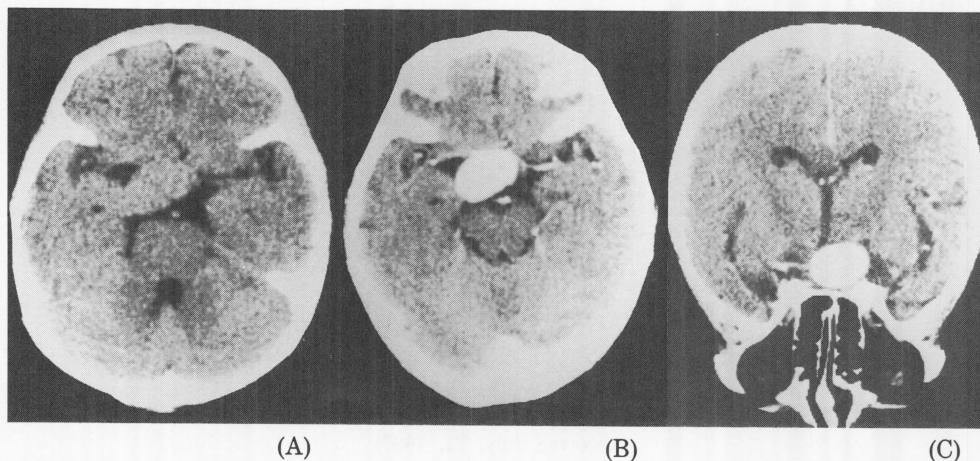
CT scans before ligation of the cervical ICA in Case 1. A plain CT scan reveals an isodense, ovale mass in the suprasellar region (A), which is intensely and homogenously enhanced after the administration of the contrast material (B, C).
